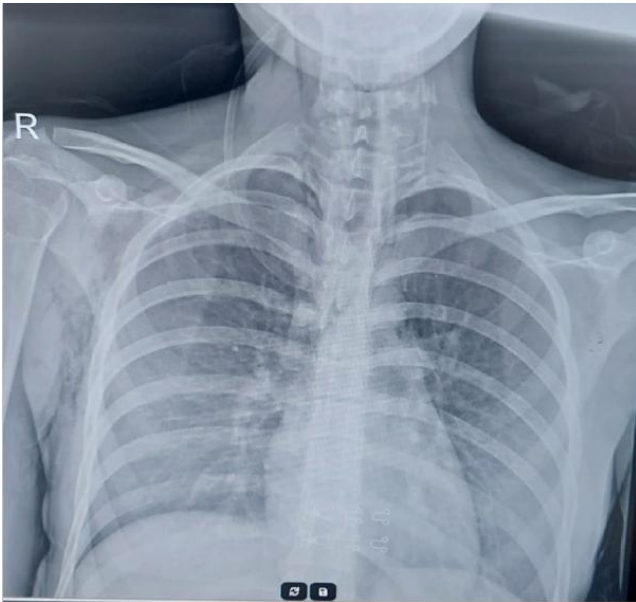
Posteroanterior chest radiograph demonstrating extensive cervicofacial subcutaneous emphysema, characterized by radiolucent air outlining the soft tissues of the neck, without evidence of pneumothorax.
